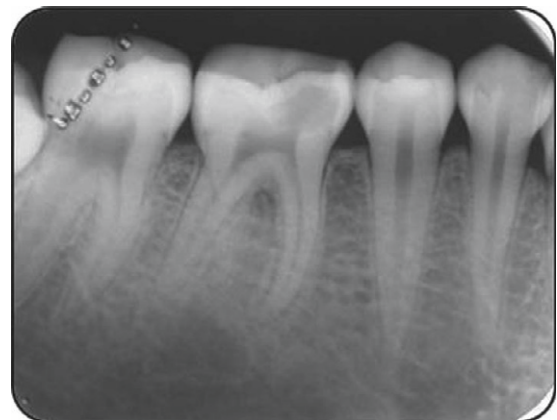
Diagnostic radiograph of mandibular right first molar.
